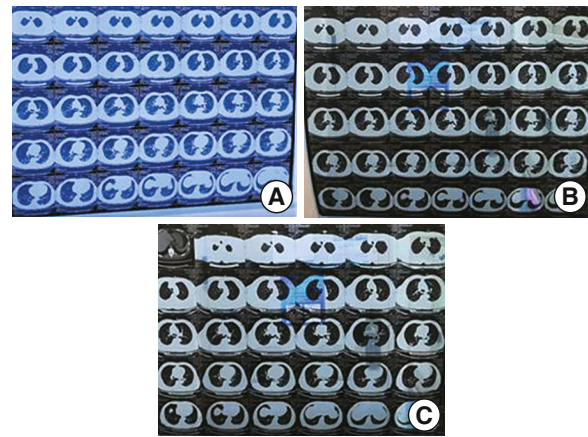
Chest CT Images on January 31, February 10, and February 24
